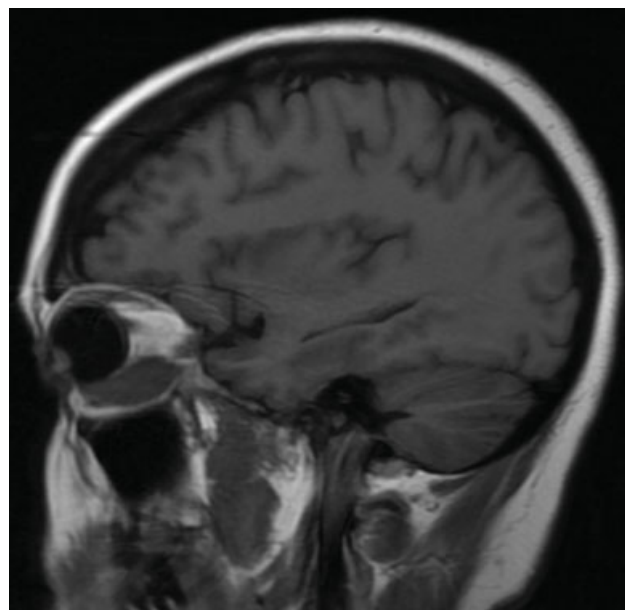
Orbital MRI demonstrated fusiform enlargement of the inferior rectus with tendinous sparing, and signal isointense to normal muscle on T1 and heterogeneously hyperintense on T2.
